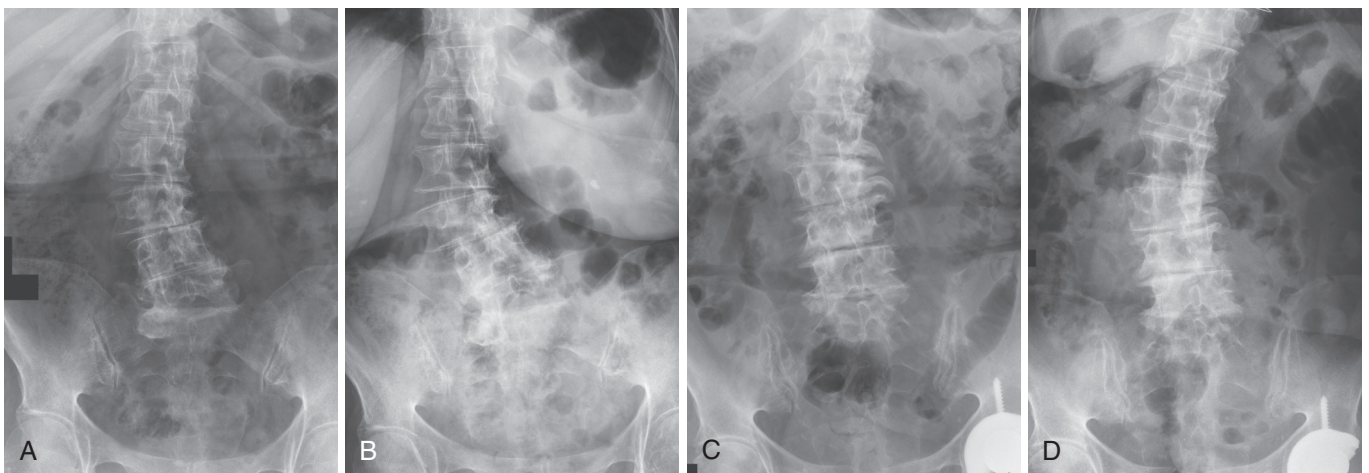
The effect of upright weight-bearing radiographs on balance and deformity. Recumbent radiograph (A) shows lumbar scoliosis with a rotatory component, which is significantly exacerbated in a subsequent upright radiograph (B). In another patient, the recumbent radiograph (C) underestimates the true scoliotic curve seen on an upright radiograph (D). Sagittal and coronal balance can only be assessed on upright, weight-bearing imaging.
